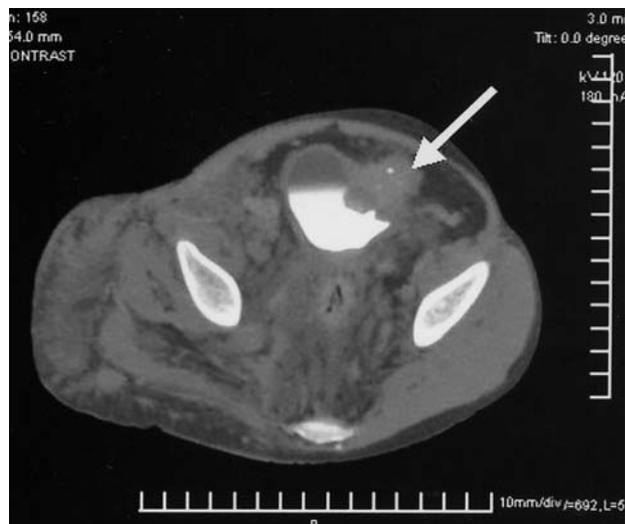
Pelvic CT scan (case #3) with intra-vesical contrast medium showing a large lesion involving the left anterior bladder wall (white arrow).
